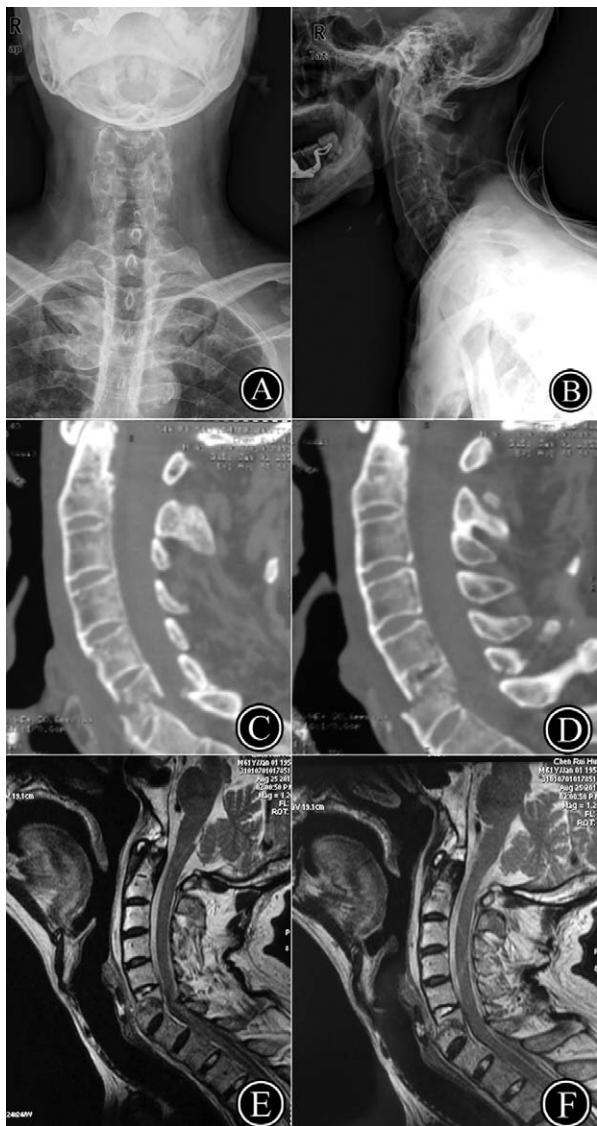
Preoperative imaging assessment. A and B, Preoperative x-ray examination suggested a typical “bamboo spine” with C6 fracture and dislocation. C and D, CT sagittal reconstruction confirmed the transverse fracture through C6 vertebral body with laminar and spinous process fracture. E and F, MRI demonstrated prevertebral edema, rupture of anterior longitudinal ligament, and compression of spinal cord.
